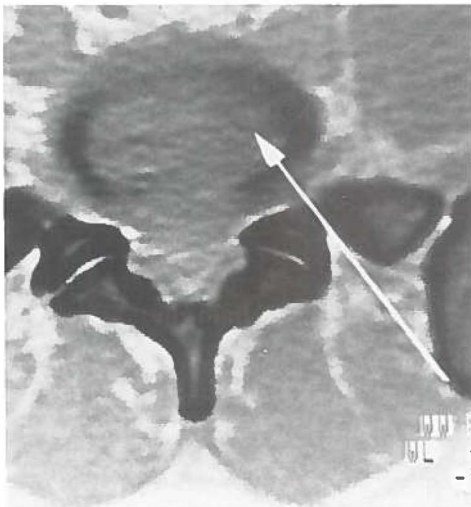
CT scan in the plane of disc level L5-S1. If a high iliac crest is present, needle placement with a straight needle often occurs in the margin of the nucleus.
